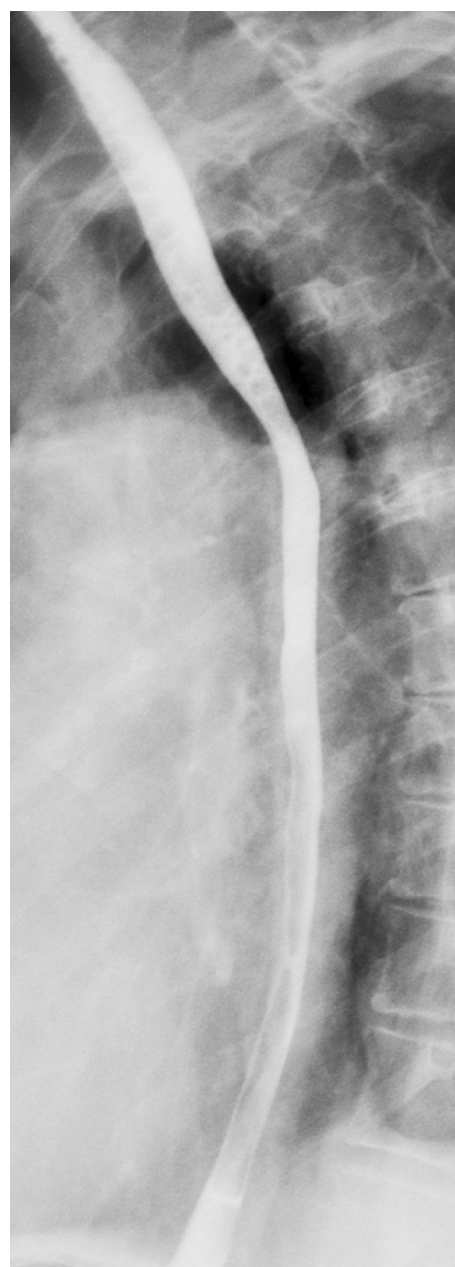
Small-caliber esophagus of eosinophilic esophagitis. Prone, right anterior oblique spot image from single-contrast esophagram shows marked loss of caliber of entire thoracic esophagus. This young man presented with longstanding dysphagia, asthma, and atopic history. The radiographic and clinical findings should be highly suggestive of eosinophilic esophagitis.
